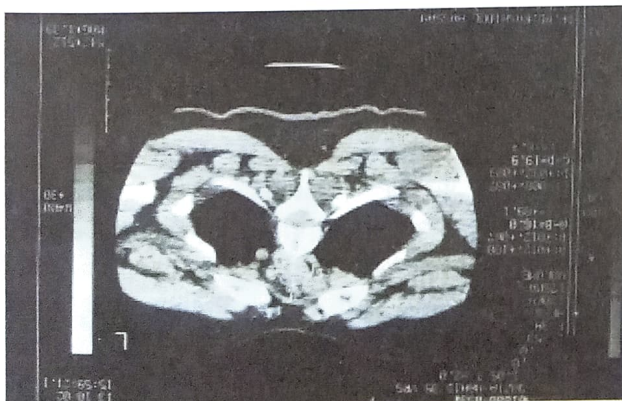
HRCT scan of chest
